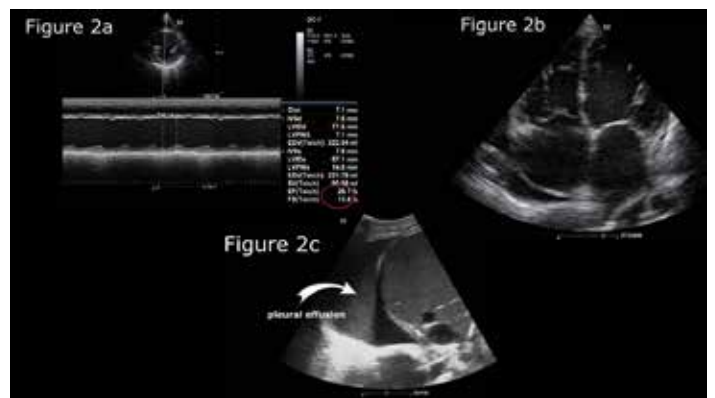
Left ventricular function assessment at parasternal short axis with Teichholz method revealed the severe reduced left ventricle ejection fraction; 2b. Echocardiographic assessment at apical four-chamber view revealed biatrial dilatation, signs of dilated cardiomyopathy, and pericardial effusion around the right atrium; 2c. At right-sided pleural assessment revealed massive pleural effusion
